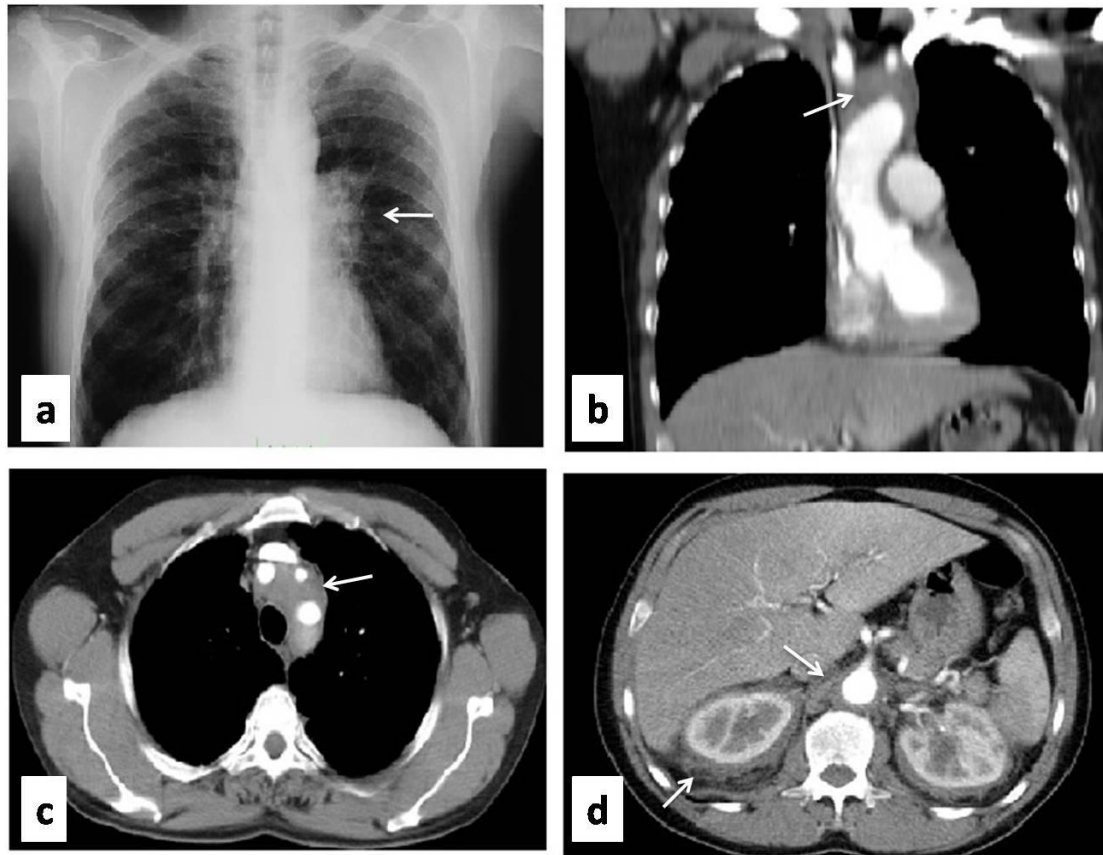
Enlargement of the left hilum at PA chest radiography (a), fibrosis in the superior mediastinum on coronal (b) and axial (c) sections at CT and retroperitoneal fibrosis in abdominal sections (d)
